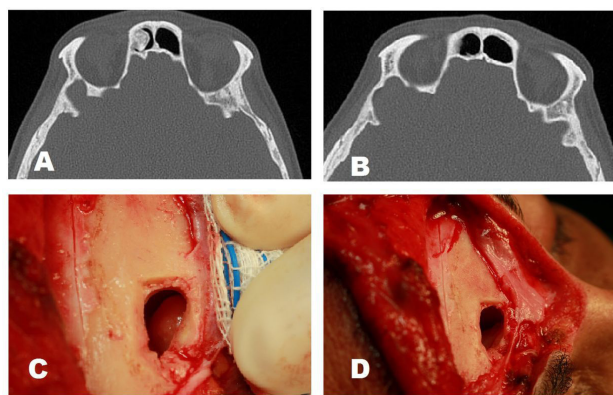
External approach to the frontal sinus osteoma. Preoperative paranasal sinus CT(A), Osteoma in the frontal sinus (B), Postoperative paranasal sinus CT (C), After removal of the frontal sinus osteoma (D).
